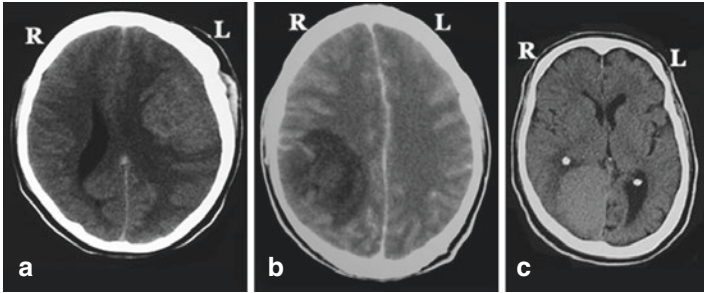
Non-contrast brain CT scan showing alterations of the normal sulcal pattern as evidence of mass effect from an isodense meningioma (a), a low-density glioma (b) and a slightly hyperdense meningioma (c)
